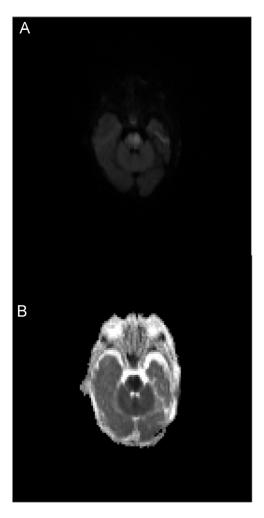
(A and B) Brain MRI, DOL 7, axial view DWI, and ADC sequences: DWI sequence shows hyperintensity in pons with corresponding decreased ADC signal.
